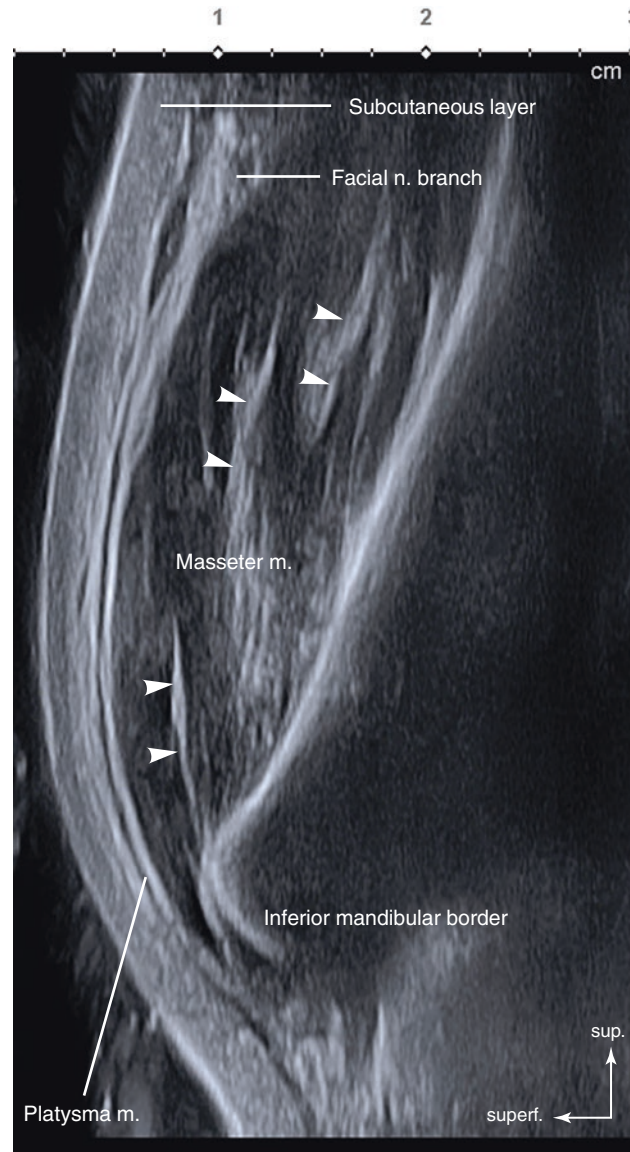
Ultrasonography of the mid-half line parallel to Ma1 and Ma3 (Ma2). B mode (coronal view, 15 MHz by linear transducer) (arrowheads: deep inferior tendons). (Published with kind permission of © Hee-Jin Kim 2020. All Rights Reserved)
